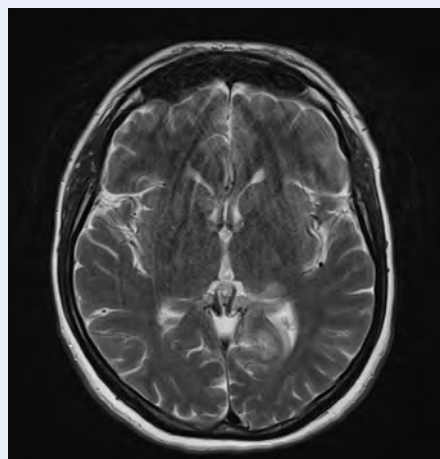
MRI showing resolving the lesion after alteplase treatment
